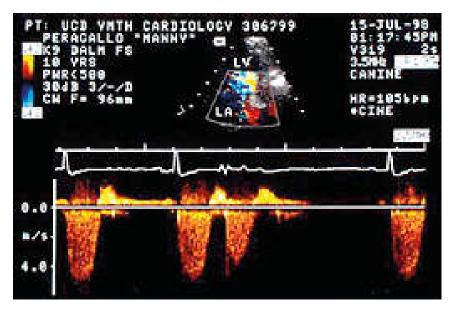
Doppler ultrasound
